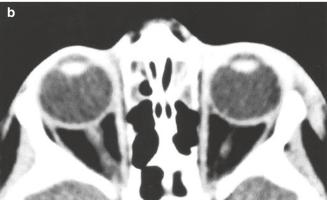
Sinusitis with preseptal inflammation. (a) This patient has edema and erythema of the left periocular region. (b) The CT scan demonstrates soft tissue edema of the eyelids, opacification of the ethmoid air cells, and normal orbital contents
